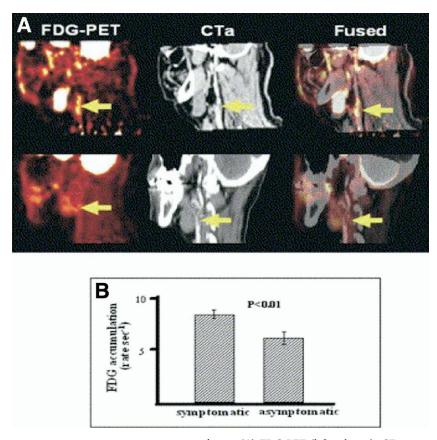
Symptomatic versus asymptomatic stenotic plaque. (A) FDG-PET (left column), CT angiography (middle column), and fused PET/CT (right column) images from patient with symptomatic carotid stenosis (top row) and contralateral asymptomatic carotid stenosis (bottom row) are shown. Arrows in the top row highlight areas of intense FDG uptake corresponding to stenotic plaque. Arrows in the bottom row highlight mild FDG localization in the plaque of the asymptomatic patient. Stenosis does not necessarily imply activity or underlying cause. (B) Graph of FDG activity in active symptomatic and inactive asymptomatic plaques. FDG uptake in symptomatic plaque was significantly higher. (Reprinted with permission from the American Society of Nuclear Cardiology.⁷⁵)
